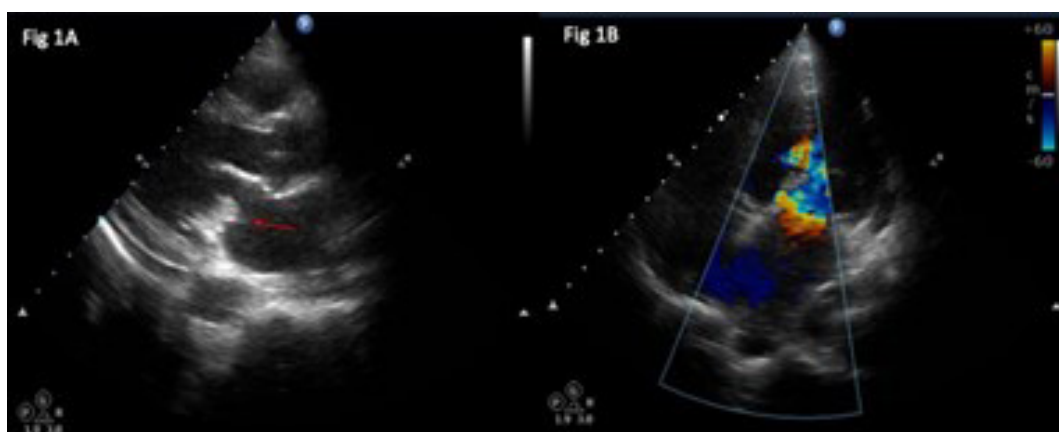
(A) Transthoracic echocardiogram shows a vegetation (arrow) on the posterior mitral valve leaflet (Parasternal long axis view). (B) Transthoracic echocardiogram shows moderate mitral regurgitation with colour doppler imaging in the apical 4 chamber view.
